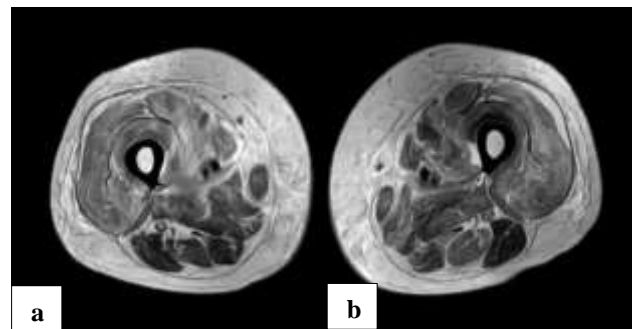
(a and b): Coronal view of the MRI of the bilateral thighs showing marked muscular and intermuscular oedema predominantly involving the anterior and adductor compartment muscles. Diffuse subcutaneous tissue swelling and oedema throughout.
